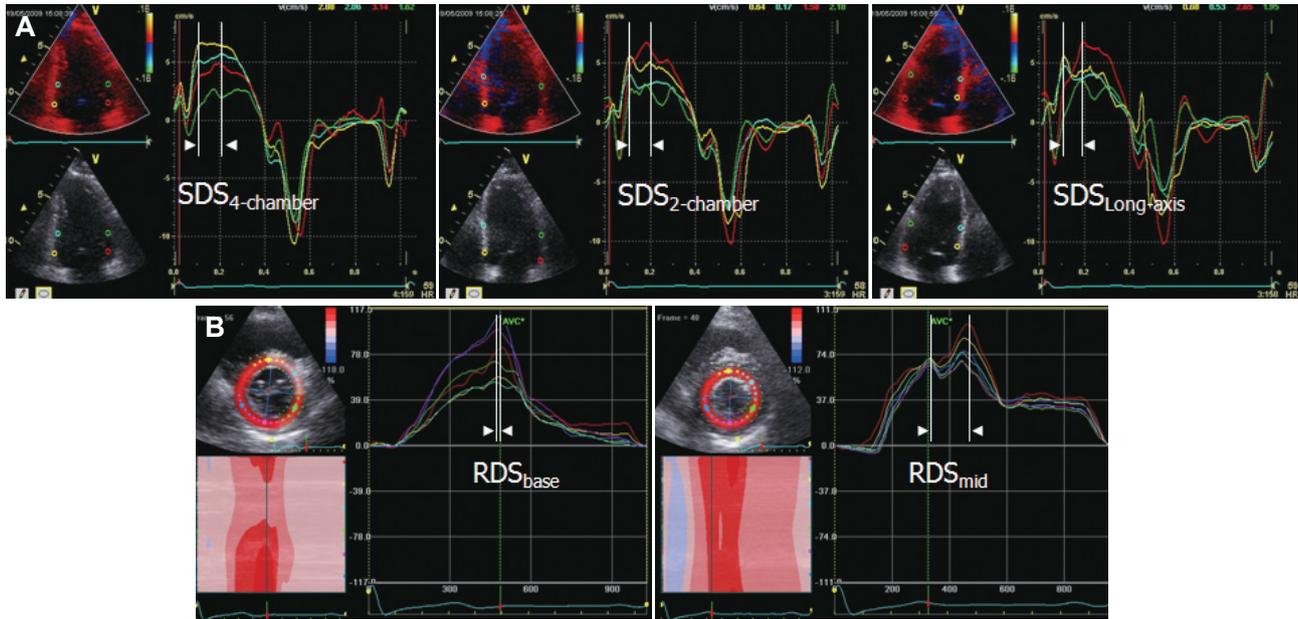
A: tissue Doppler time-velocity curves were derived from 12 segments measured at basal and mid levels from 4-, 2-chamber and long-axis views. A time difference between the shortest and longest time of the peak myocardial systolic velocities among the 12 segments was defined as LV systolic dyssynchrony (SDS_{LV}). B: speckle tracking time-strain curves of six-radial sites were measured from mitral (RDS_{base}) and papillary muscle levels (RDS_{mid}) of parasternal short axis views.
